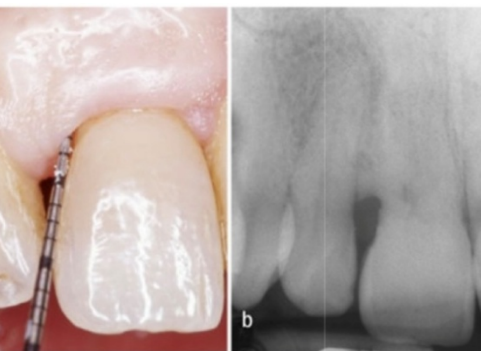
20 year follow-up. a) The clinical view shows 3 mm of residual probing depth. Due to “creeping attachment” of the marginal tissue over time, recession was reduced to 1mm at central and lateral incisors. b) the 20 years radiograph shows the complete bone fill of the defect. The distance between bone-crest / CEJ is 2.5 mm.
